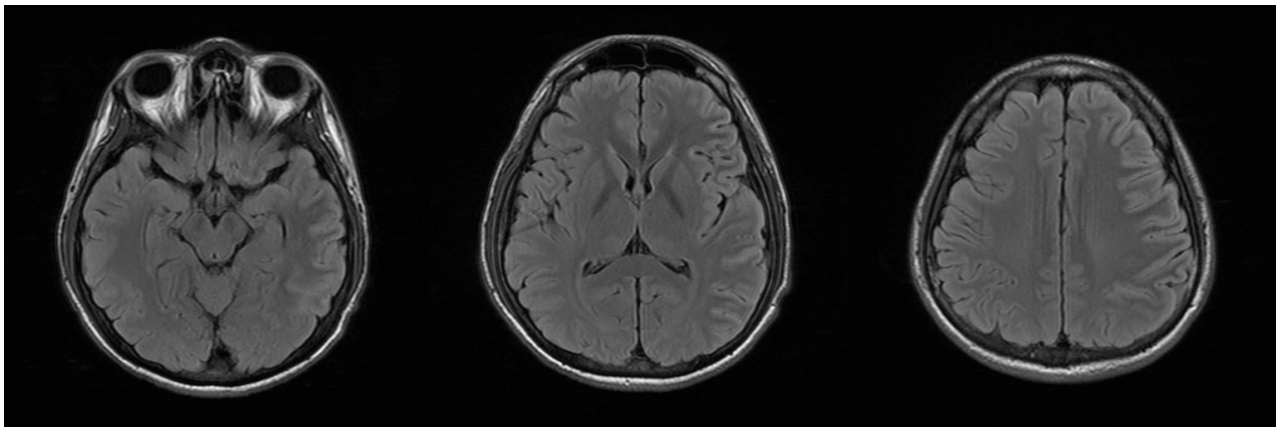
Precontrast magnetic resonance imaging of the brain revealed diffuse swelling in the left cerebral cortex.
